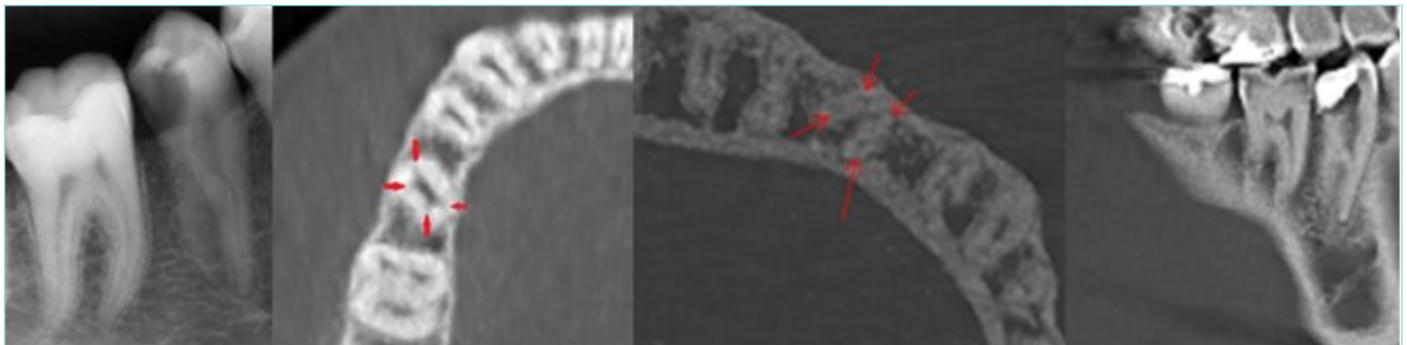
Case 2 preoperative and cone-beam computed tomography figure.
